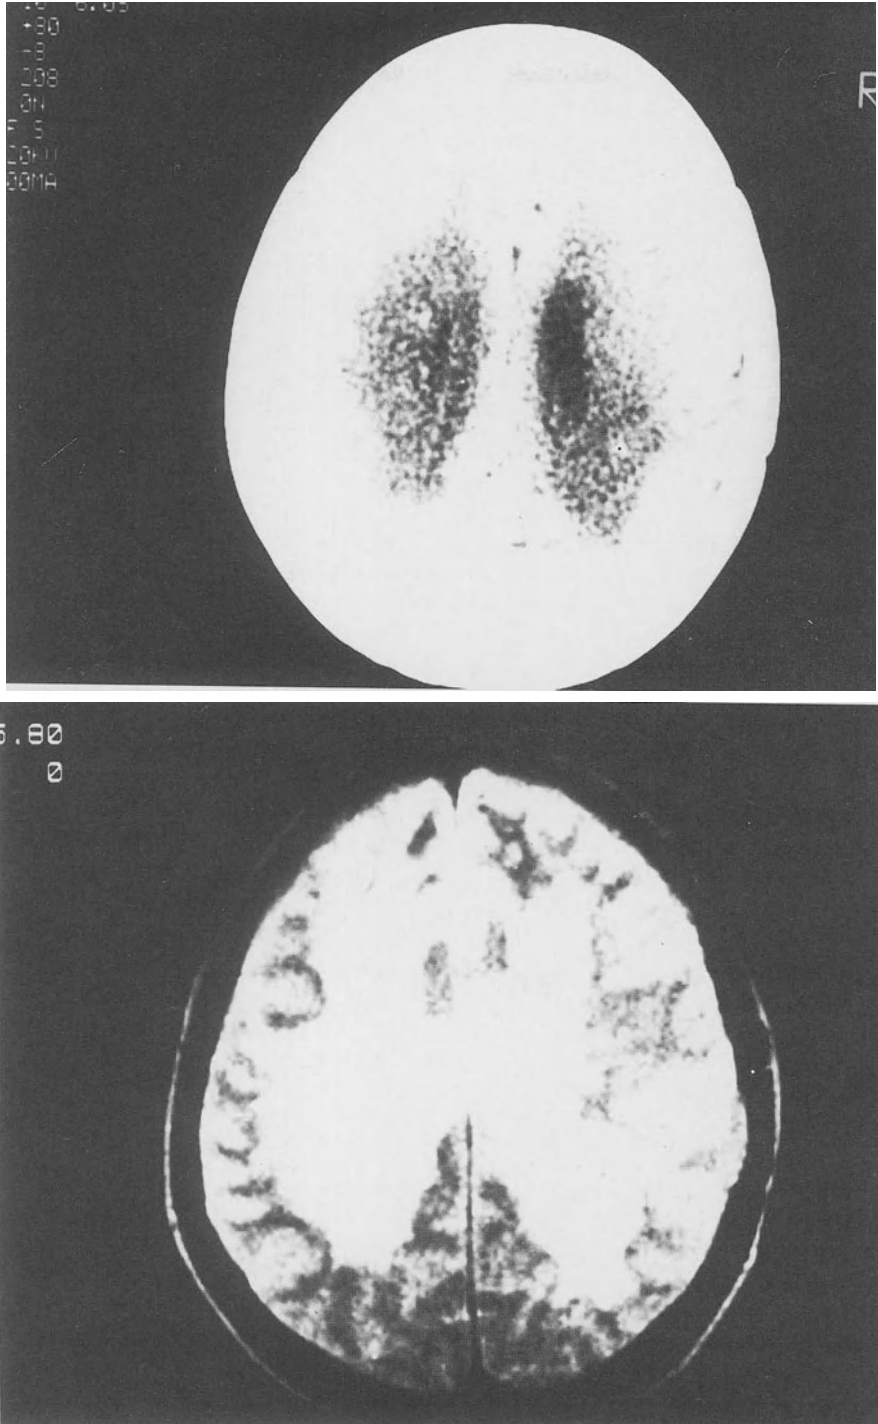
Delayed leukoencephalopathy after radiotherapy with unconventional fractionation: a CT scan; b MR image
